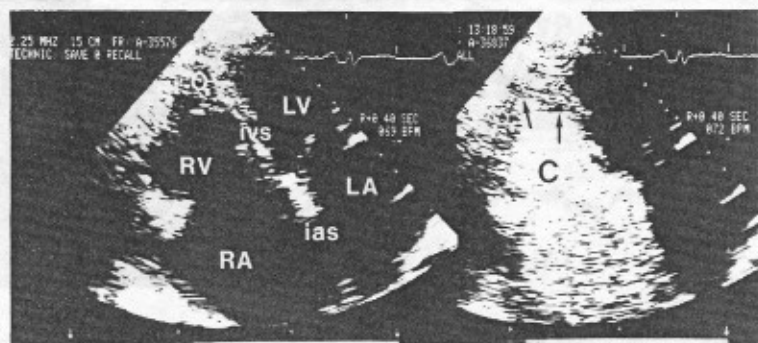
Apical four-chamber view, taken 11 months later, showing right ventricular apical obliteration in same patient as Fig. 6. Changes developed, despite excellent clinical response to oral prednisone. *Left panel* shows RV apical obliteration before and after (*right panel*) agitated intravenous saline solution contrast (C) delineated RV cavity and "horseshoe" apical lesion. IVS and LAS, Interventricular and interatrial septum. Other abbreviations are given in previous figures. (From Acquatella H, Schiller NB, Puigbo JJ, Gomez-Mancebo JR, Suarez C, Acquatella G. *Circulation* 1983;67:1223. Reprinted with permission of the American Heart Association.)
